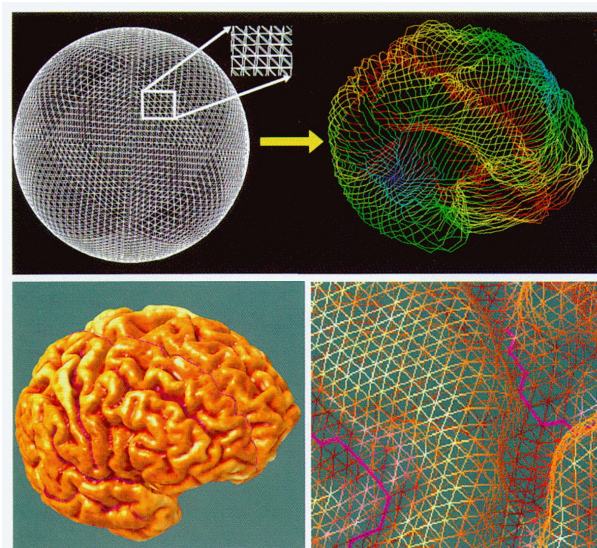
First Steps of Cortical Surface Mapping. A spherical mesh grid is progressively deformed to match a target boundary intensity in the 3D-MRI (Top). The resulting 3D cortical surface (Bottom Left) is high-resolution mesh of triangular elements (Bottom Right). Adapted from Thompson *et al.* [29].
